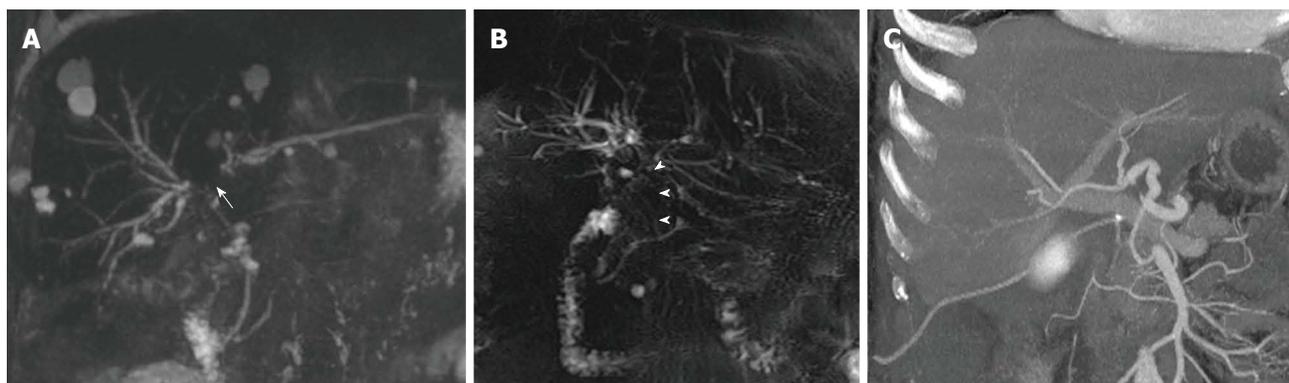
Nonanastomotic strictures in two different transplanted patients. A: MIP reconstruction shows early effects of HAT in a 58-year-old subject with hepatitis B virus infection, consisting in a stricture of the hepatic confluence (arrow) and multiple intrahepatic bilomas; B: ITBL in a 68 male patient transplanted for alcoholic cirrhosis. 2D MRC image shows a stricture of the hepatic confluence extended to the donor common hepatic duct (arrowheads); C: CT angiography found patent hepatic artery in this patient. MRC: Magnetic resonance cholangiography; MIP: Maximum intensity projection; ITBL: Ischemic-type biliary lesions.
